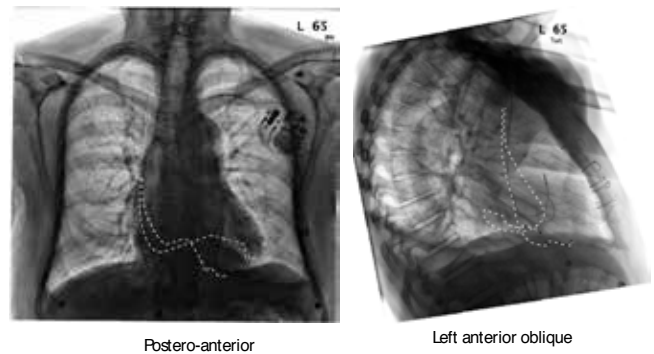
Chest X-rays showing bipolar and quadripolar leads in different side branches of the coronary sinus
